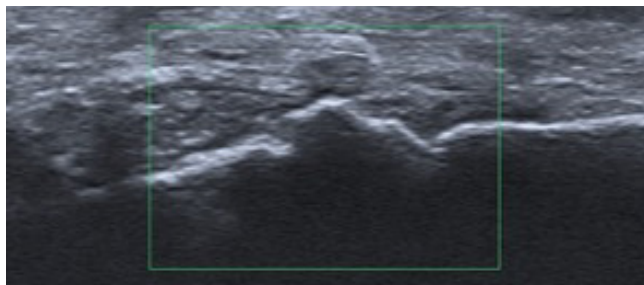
Ultrasound of the right hand shows thickening of the synovial membrane in the radiocarpal joint, with crystals and without hyperemia
